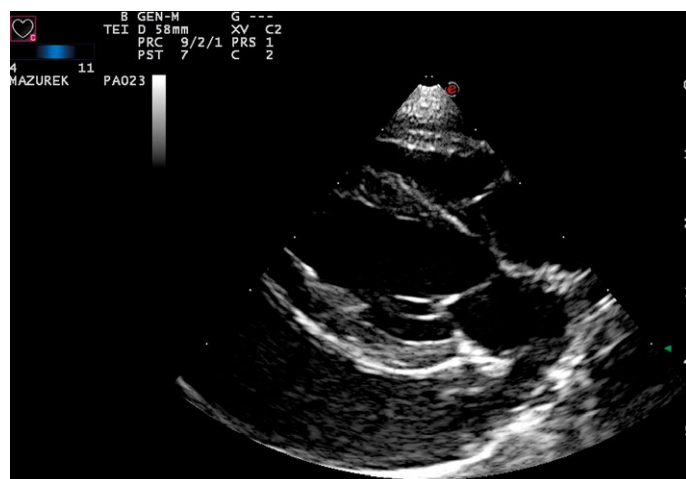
Right-sided, parasternal four chamber long axis view. A large amount of fluid was visible in the pericardial sac, and a collapse of the right atrium lumen during expiration was present
